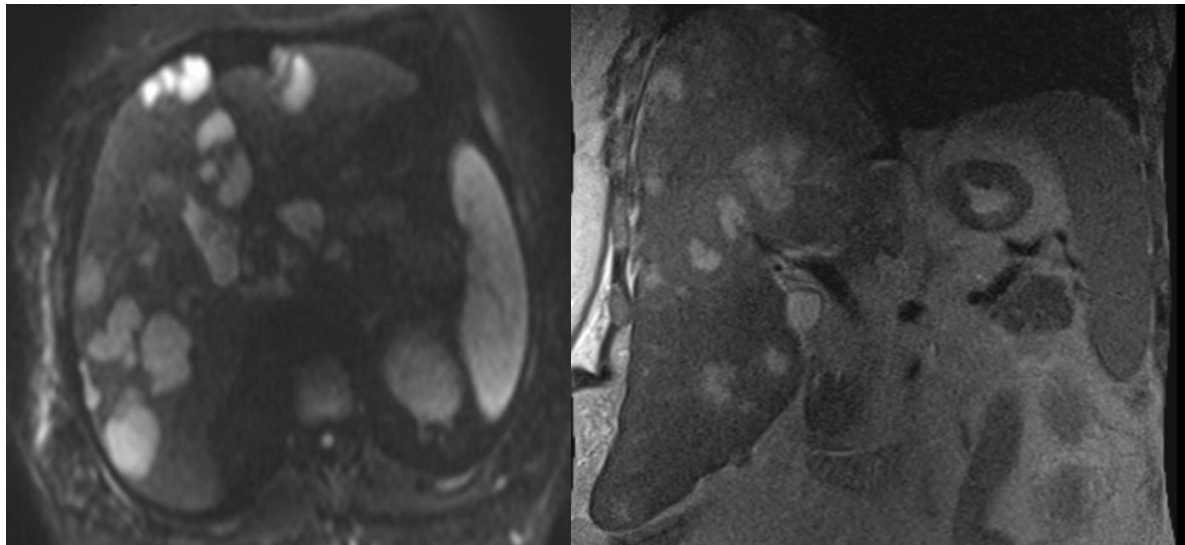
MRI showing multiple masses in the liver
